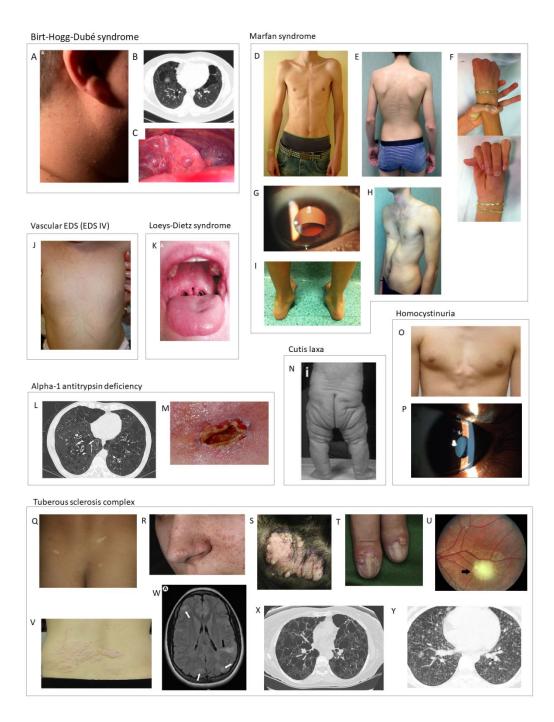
Physical exam findings of pneumothorax-associated syndromes. (a-c) Birt-Hogg-Dubé syndrome (BHDS). a. Fibrofolliculomas of the neck (164). b. Lung cysts and bullae; extraapical location is characteristic (164). c. Pleural blebs on the surface of the left lower lobe; these can be missed on CT but seen during thoracoscopy/VATS (164). (d-j) Marfan syndrome. d.
